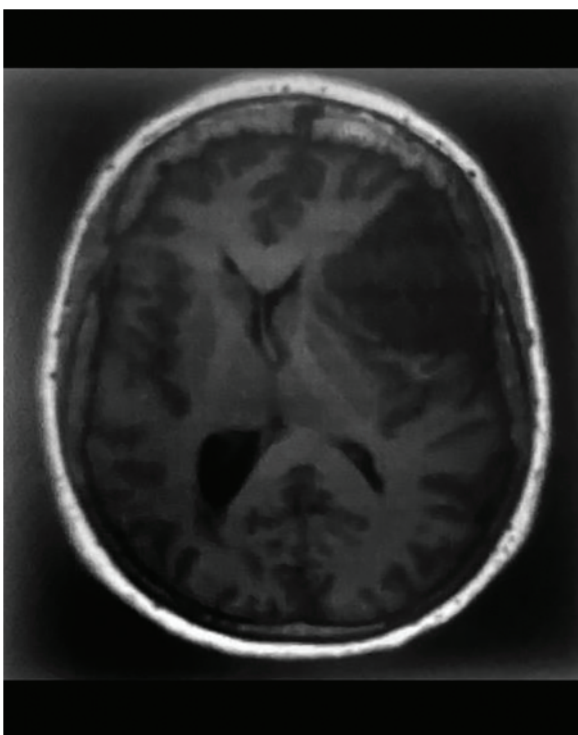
Brain MRI image axial section T1 sequence showing hypointense extra-axial lesion with mass effect on the frontotemporal region.
